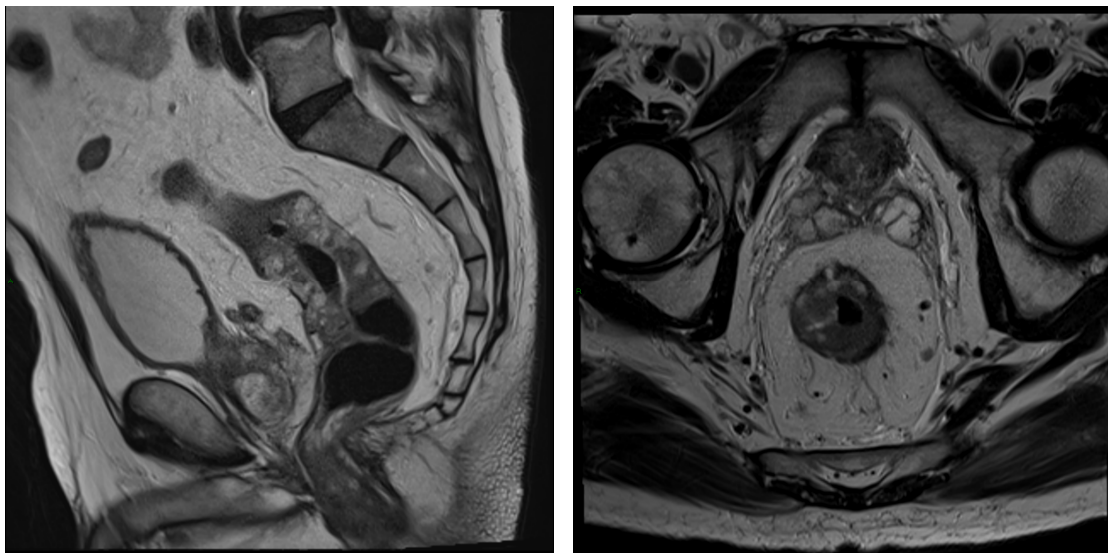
shows rectal cancer in a Pelvic MRI scan
